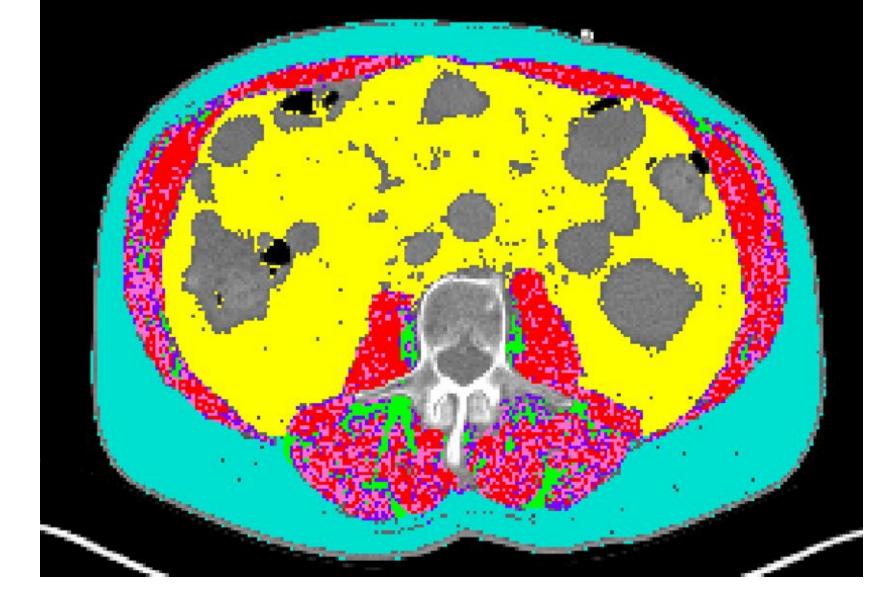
(left): CT scan of a patient at the L3 level using sliceOmatic<sup>™</sup> to obtain the skeletal muscle index for analysis. Mean radiation attenuation (MRA) and inter/intra-muscular adipose deposition may be determined following tissue segmentation.
